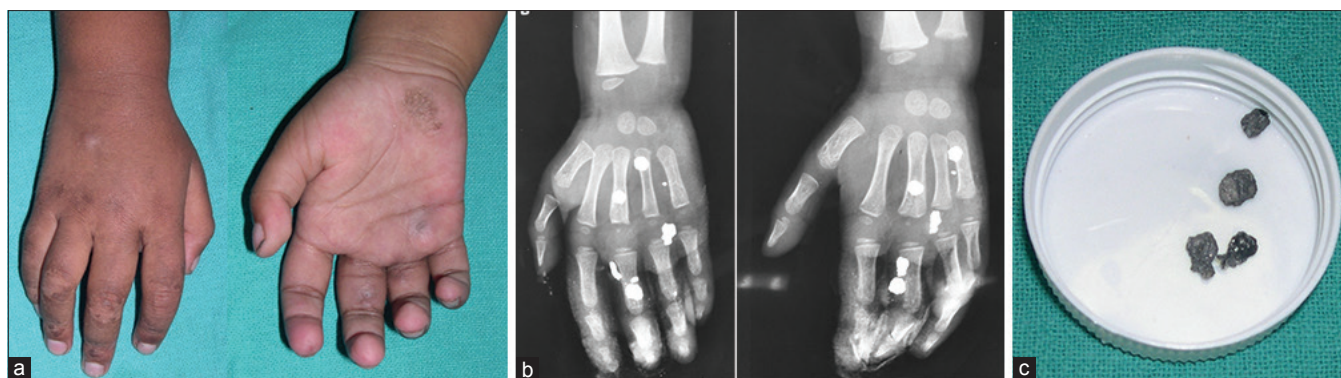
(a) Clinical photograph showing palpable pellets in the right hand of a 3-year-old child. The child suffered from weak grip (b) Plain radiographs of hand anteroposterior and oblique views showing pellets (c) Extracted pellets
